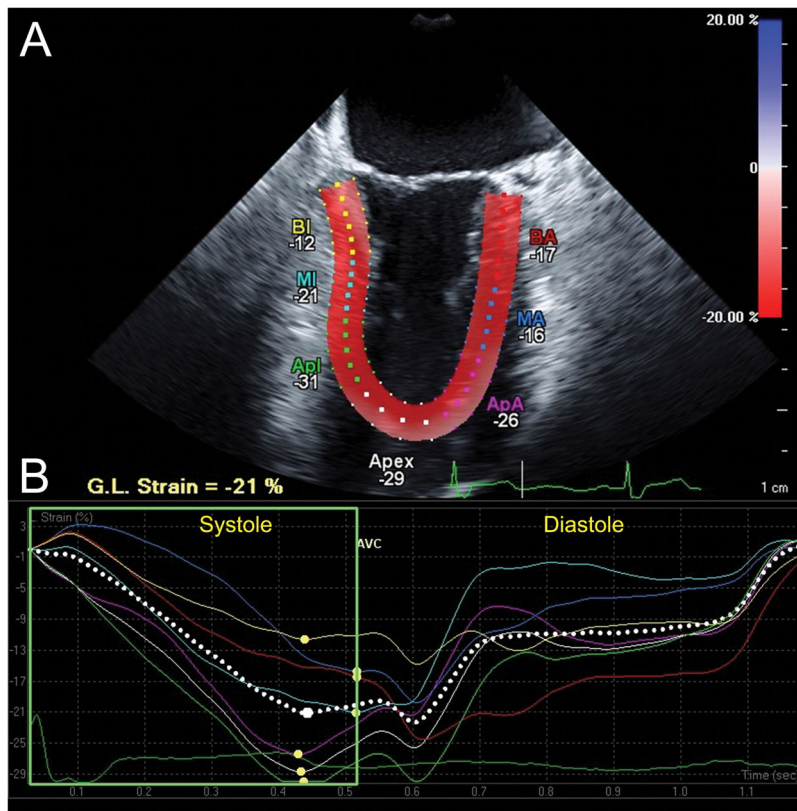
Longitudinal strain analysis assessed with Cardiac Motion Quantification (CMQ) (Philips Medical Systems, Andover, MA). (A) Mid-esophageal two-chamber echocardiographic view depicting the left ventricle (LV), where the myocardial walls are divided into six segments distinguished by color-coded labels and dots. Segmental strain measurements are shown adjacent to each segment. The myocardium is colored in shades of red corresponding to percent longitudinal shortening (strain) measured by the red-to-blue scale on the upper right-hand side. (B) Longitudinal strain curves, which are color-coded to correspond to myocardial segments in panel A, with time on the X-axis relative to the cardiac cycle and percent shortening (strain) on the Y-axis, demonstrate shortening during systole and returning to baseline at end-diastole. The pink curve, for example, represents the apical anterior wall which experiences peak shortening of -26% during systole (yellow dot identifies *peak systolic strain*). In contrast, *end-systolic strain*, measured at time of aortic valve closure (AVC), measures -23% , demonstrating that peak strain may differ from end-systolic strain. The dotted white curve represents global longitudinal strain. BA =Basal anterior; MA =Mid anterior; ApA =Apical anterior, BI =Basal inferior; MI = Mid inferior; Apl =Apical Inferior myocardial walls. G.L. Strain =Global longitudinal strain. AVC =aortic valve closure. “Reprinted with permission, Cleveland Clinic Center for Medical Art & Photography © 2013. All Rights Reserved.”
